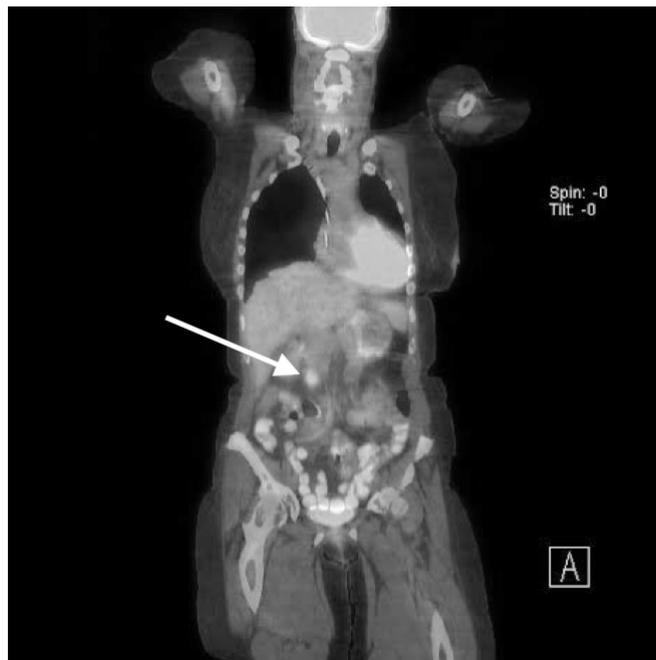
PET-CT imaging with ^{18}F -FDG displaying a hypermetabolic focus. This suggests an enlarged lymph node adjacent to the superior mesenteric vein and inferior to the splenoportal confluence abutting the pancreatic head. The focus demonstrates a maximum SUV of 4.12. The 8 mm right inferior hepatic lesion seen on a previous CT scan is below the resolution of the PET-CT.
